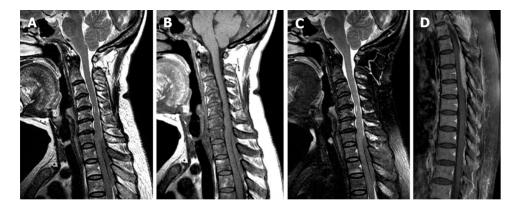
Magnetic resonance imaging showed a posterior spinal epidural mass located from C7 to T3. A: T1-weighted imaging (T1WI); B: T2weighted imaging (T2WI); C: T2-weighted fat-saturation imaging; D: Sagittal T1WI of the spine with contrast. The lesion appeared isointense on T1WI, T2WI, and T2weighted fat-saturation imaging. The spinal cord was significantly compressed, and the dural sac between the mass and spinal cord showed a hypointense signal on all sequences, indicating an extradural tumor location. T1WI showing decreased marrow signal intensity in the vertebrae, suggesting diffuse marrow infiltration. Sagittal T1WI of the spine with contrast showing anterior displacement of the spinal cord with moderate enhancement of the mass.
